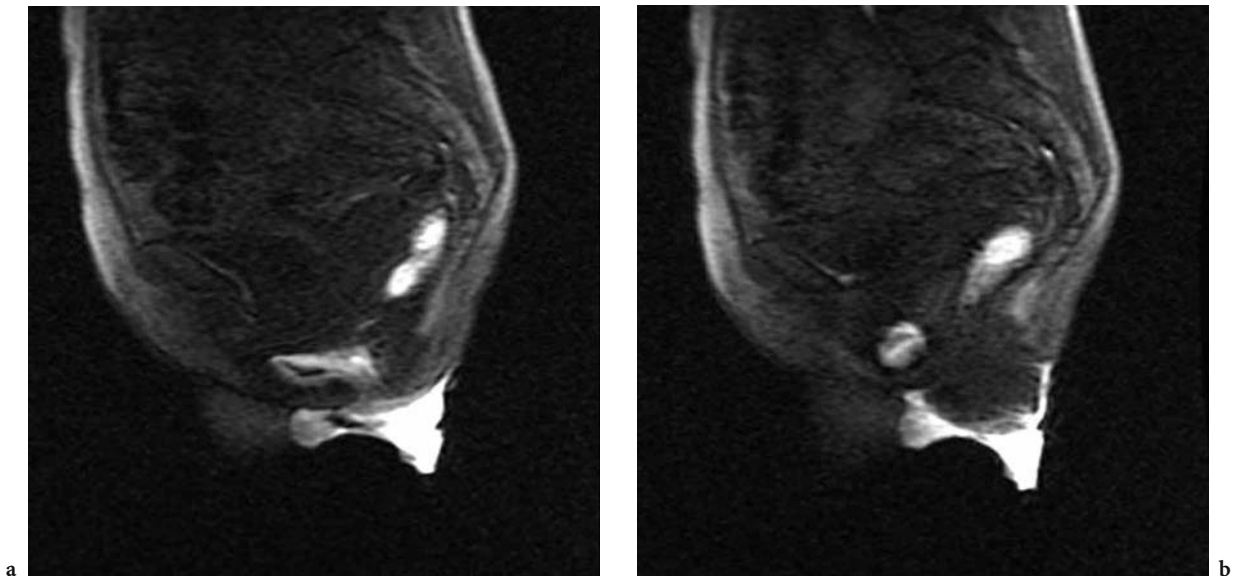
44. Complete rectal prolapse in a 35-year-old woman. Dynamic magnetic resonance imaging at rest (a) and during evacuation (b)
